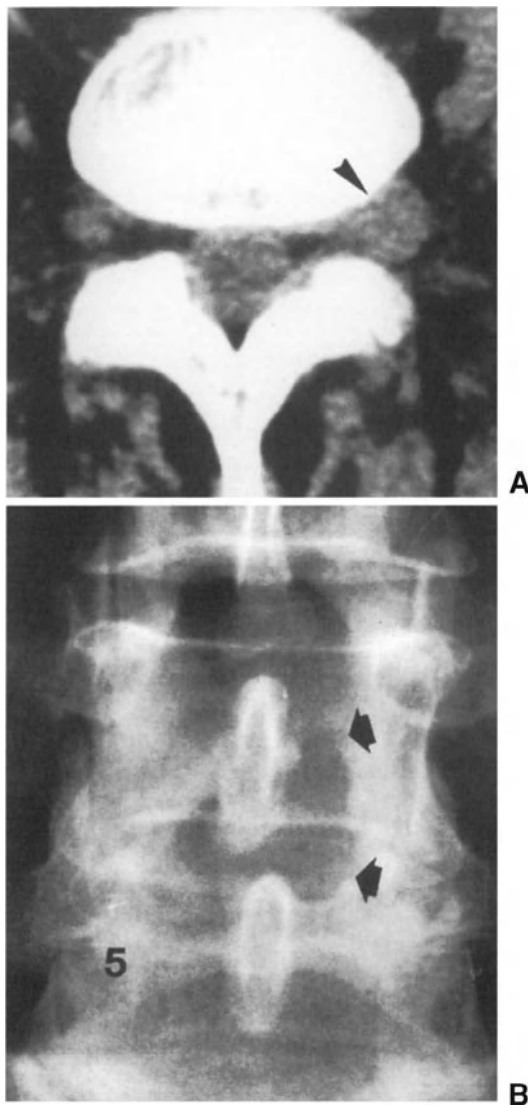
Preoperative CT scan and postoperative radiograph of a patient who underwent surgery for an extraforaminal herniation. (A) CT scan showing an L4-L5 extraforaminal herniation on the left (arrowhead). (B) Postoperative radiograph showing the laminotomy carried out to remove the herniation (arrows). The articular processes were undercut to allow removal of the herniation with no extensive arthroectomy.
